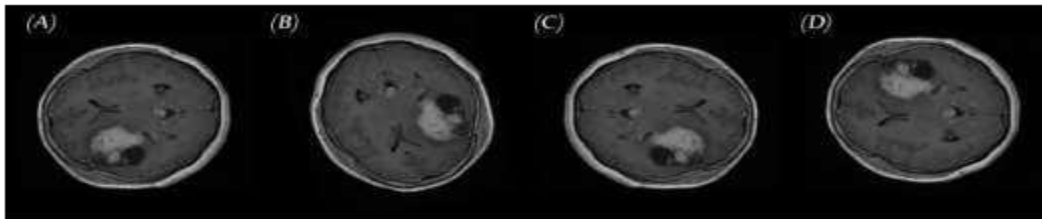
Samples of brain tumor MRIs and results of augmentation: (A) primary MRI, (B) rotation, (C) left-right mirroring, and (D) up-down flipping.
